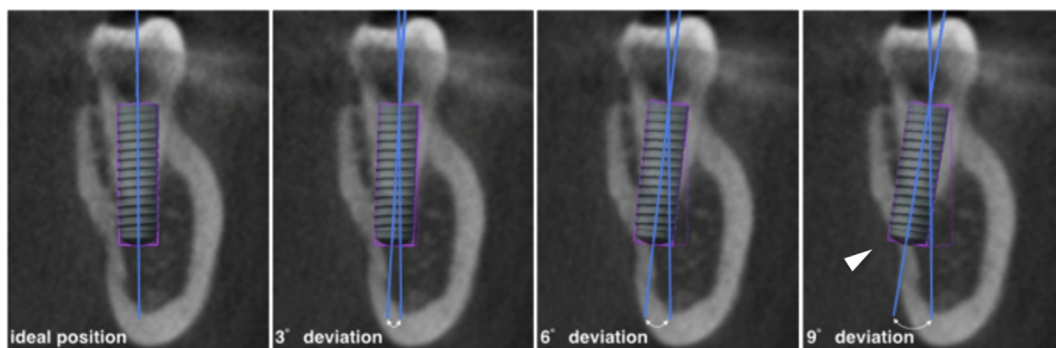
CBCT images of virtual immediate implant placement (VIIP) at the ideal implant position or lingual angulations of 3, 6, or 9 degrees. Lingual bone plate perforation was noted in VIIP at a 9-degree deviation. The bone plate perforation (BPP) was assessed and identified when the virtual implant apical outline was cross over the border of alveolar bone (the white arrow head).
